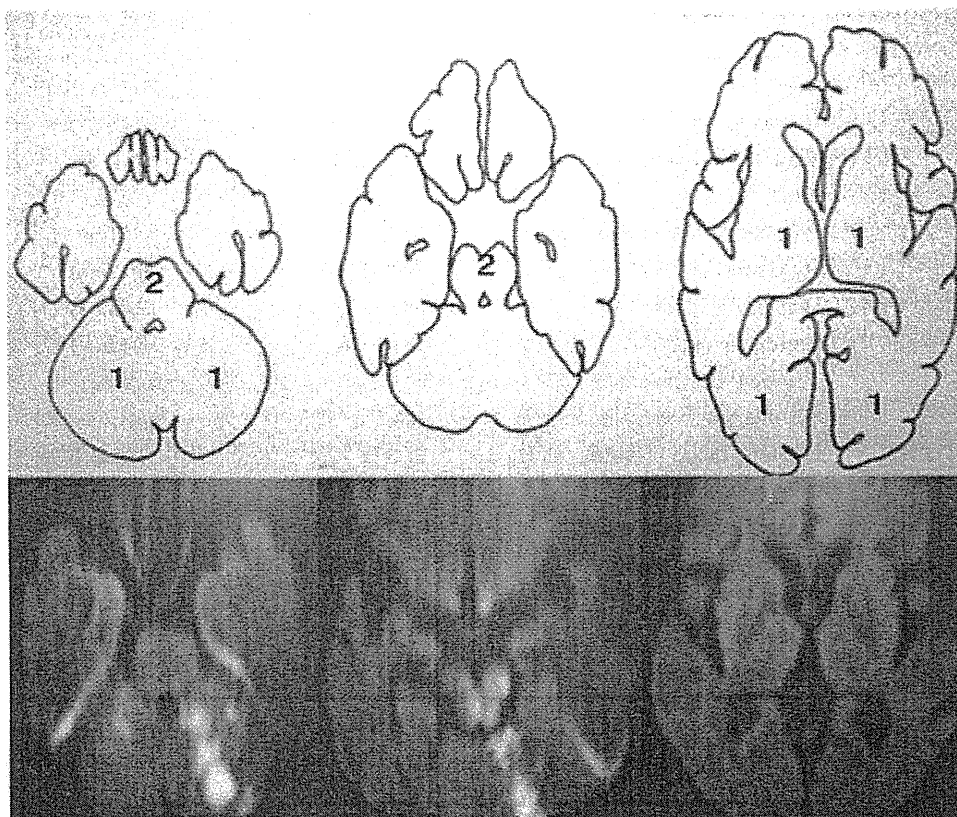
Top row* Posterior circulation ASPECTS (pc-ASPECTS) scoring system, as described by Puetz et al. [24] applied to DWI as a 10-point scoring system for evaluation of ischemic lesions in the posterior circulation. From an initial score of 10, we subtracted 1 point for each high-intensity lesion seen on DWI in the left or right thalamus, cerebellum, or posterior cerebral artery, and subtracted 2 points for each high-intensity lesion seen in any part of the midbrain or pons. A pc-ASPECTS score of 10 indicates the absence of visible
